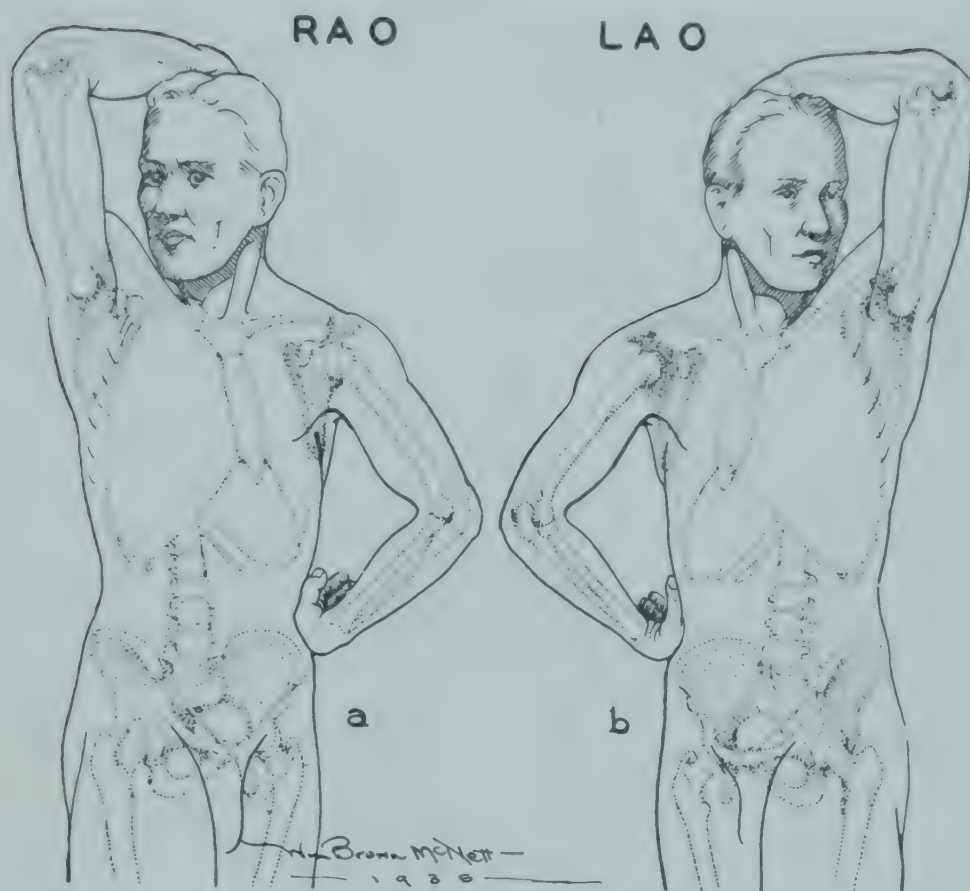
Positions for anterior oblique views. Degree of rotation is to be determined for each individual by means of fluoroscopy. *a*, Right anterior oblique view; *b*, left anterior oblique view. Roesler, H.: Clinical Roentgenology of the Cardiovascular System, Charles C Thomas.
